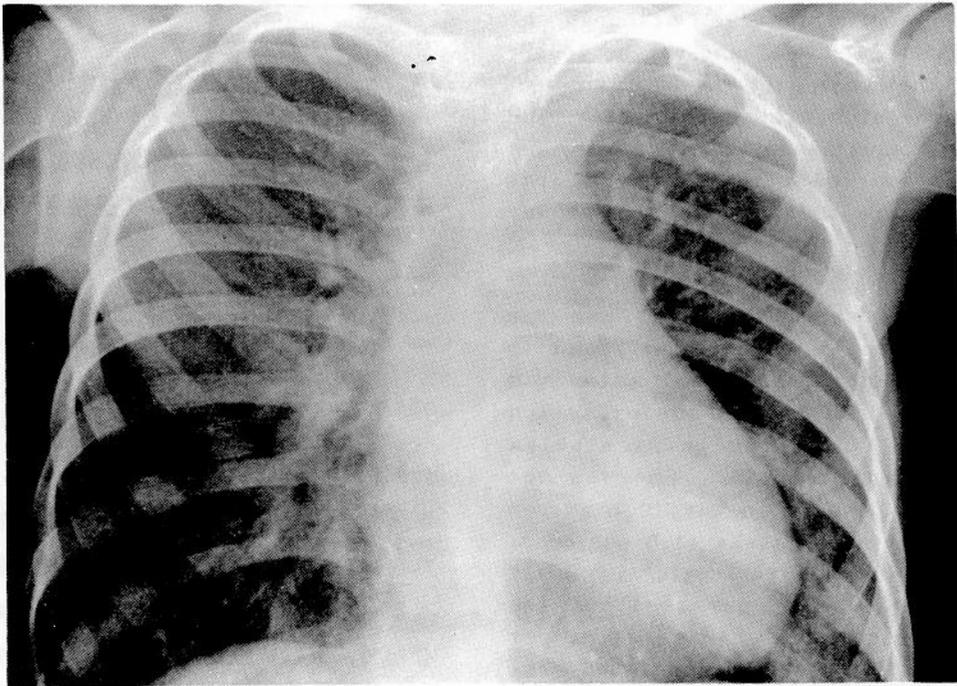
CHEST ROENTGENOGRAM MARCH 22, 1960 SHOWS RESOLUTION OF RIGHT LUNG FIELD OPACIFICATION
